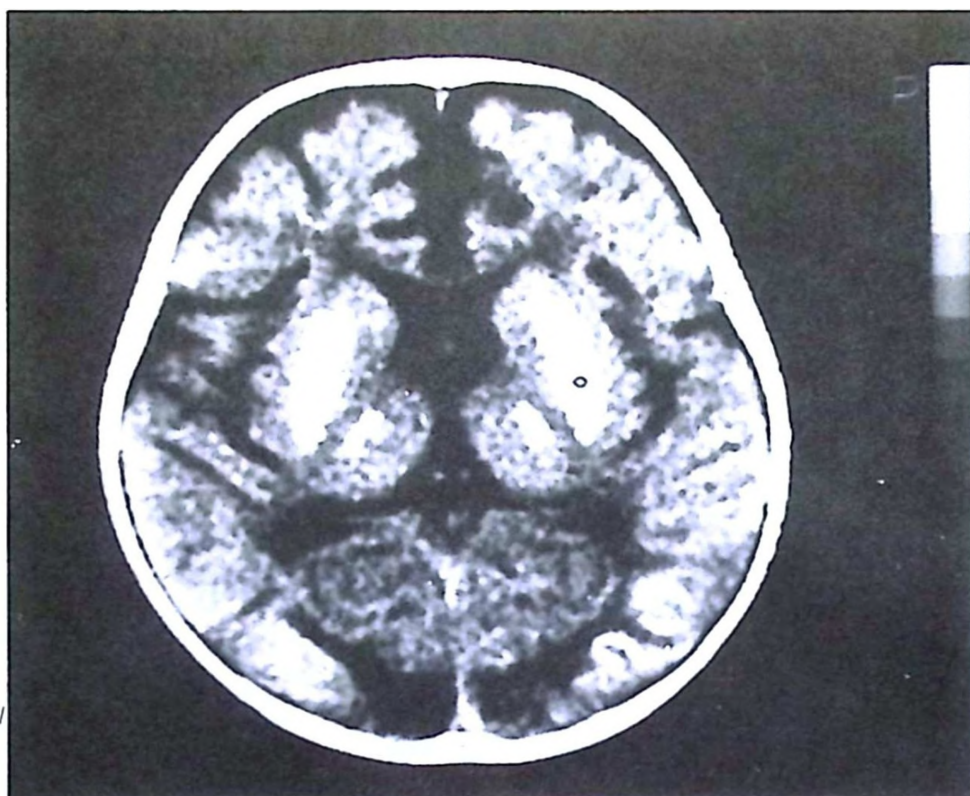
a, b: The CT images, which are not enhanced, show bilateral symmetric calcification of lentiform and thalamic nuclei and of the cortico-medullary junction in the parieto-occipital lobes (Case 1).
